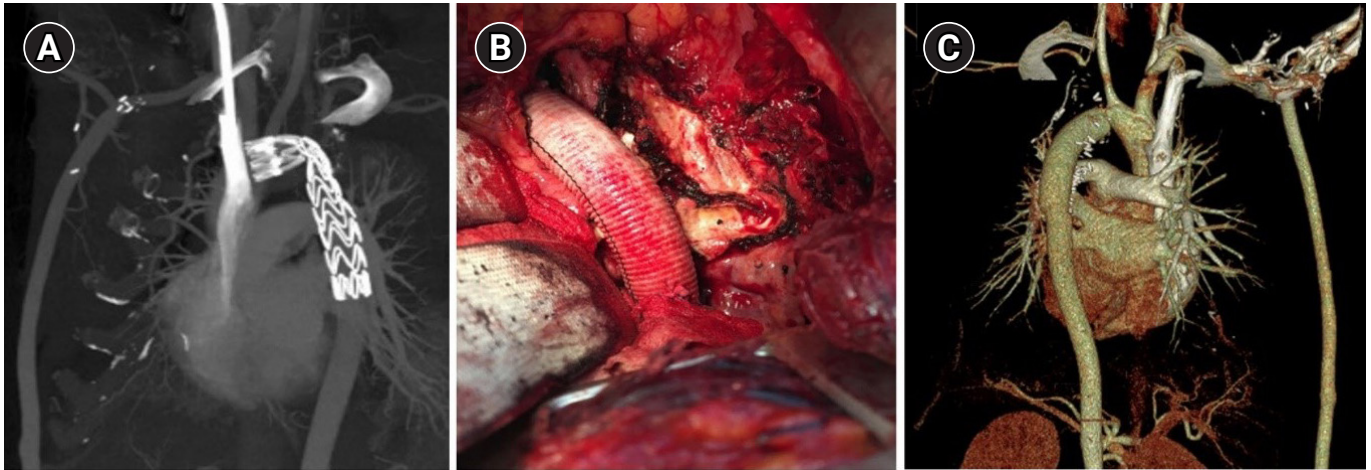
Computed tomography (CT) scan after thoracic endovascular aneurysm repair, without any definite endoleak (A). The new Dacron graft in the operative findings (B) and a postoperative CT scan (C).
